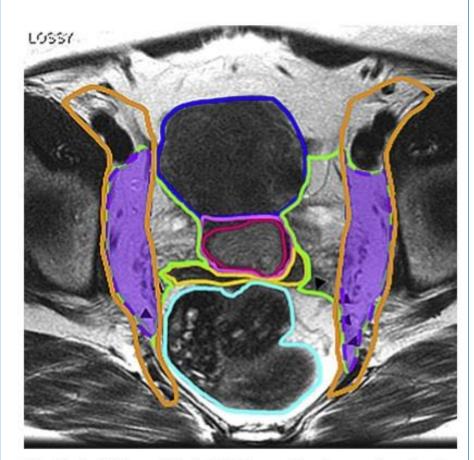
Axial T₂-weighted MR image showing overlap (purpleshaded region) between nodal clinical target volume (orange contour) and lateral portion of parametrial volume (green contour).
